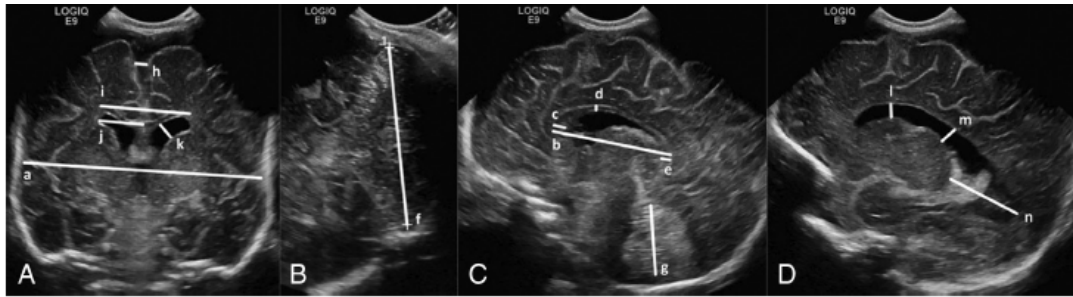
Cranial ultrasonography linear measures: images through the anterior fontanel in the coronal plane at the level of foramina of Monro (A) and the sagittal (C) and parasagittal (D) planes, and an image through the mastoid fontanel in the coronal plane posterior to the fourth ventricle (B). Brain tissue: biparietal diameter (a), corpus callosum length (b), corpus callosum genu width (c), corpus callosum body height (d), corpus callosum splenium width (e), trans cerebellar diameter (f), and vermis height (g). Fluid spaces: interhemispheric distance (h), ventricular width (i), ventricular index (j), anterior horn width (k), anterior horn height (l), ventricular midbody width (m), and thalamo-occipital distance (n).
